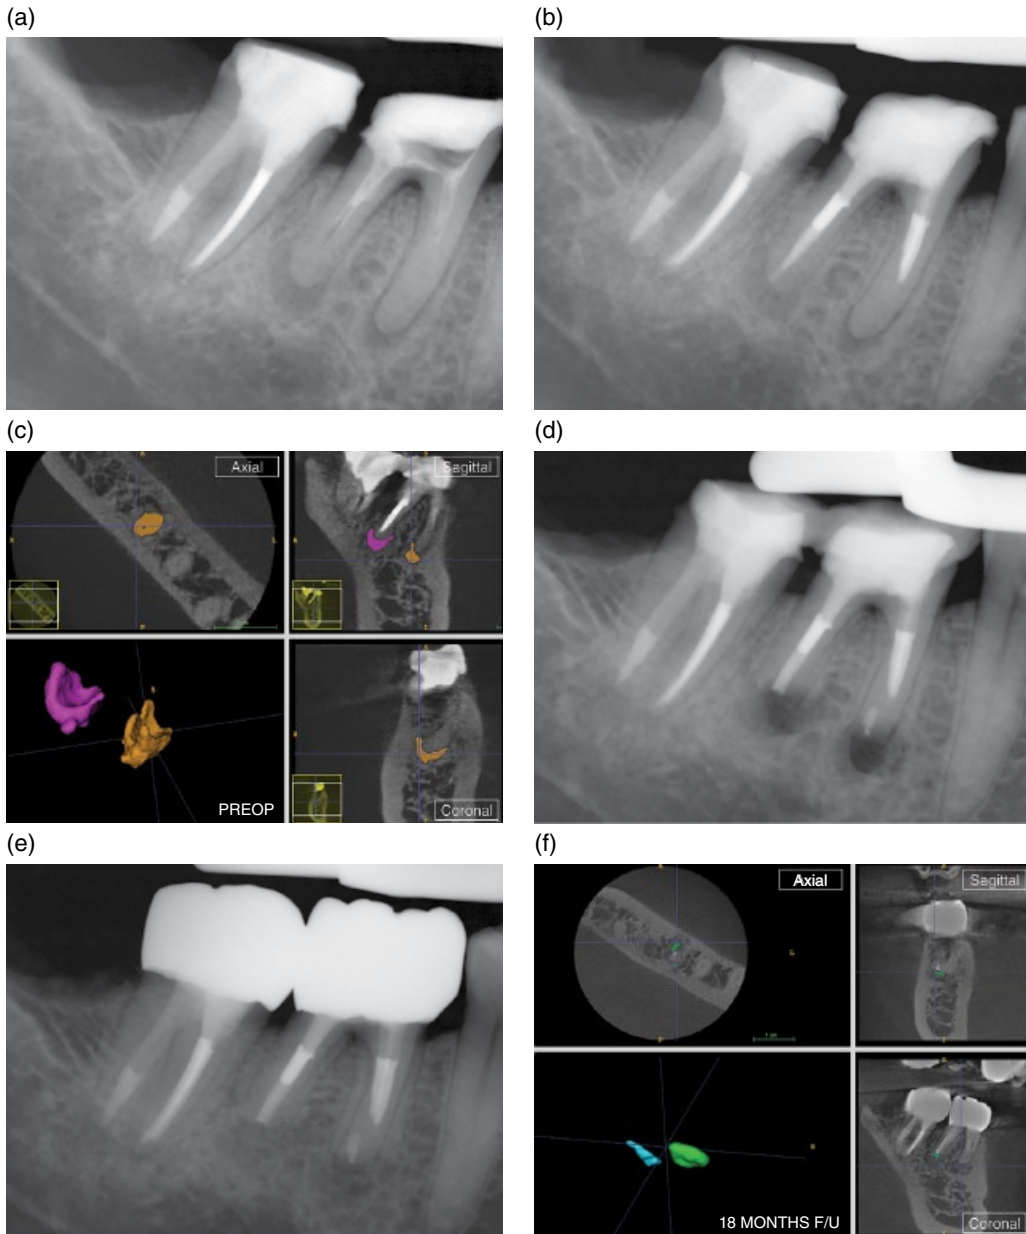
Outcome evaluation comparing conventional 2-dimensional radiography with 3-dimensional CBCT imaging after surgery on mesial root of a first right mandibular molar. (a) Preoperative radiograph prior to non-surgical retreatment. (b) Postoperative radiograph after retreatment. Note that the mesial root canal system could not be negotiated. Presence of clinical symptoms. (c) Preoperative 3-dimensional segmentation of periapical lesions. (d) Postoperative radiograph after surgical procedure with mesial root-end filling (MTA). (e) 18-months follow-up radiograph. Radiographic healing observed, no clinical symptoms. (f) Three-dimensional segmentation of remnant low density areas identified in CBCT image, allowing for volumetric comparison and more precise assessment of periapical areas (follow-up CBCT imaging approved by institutional review board). Courtesy of Dr Tom Schloss, Nuremberg, Germany.
